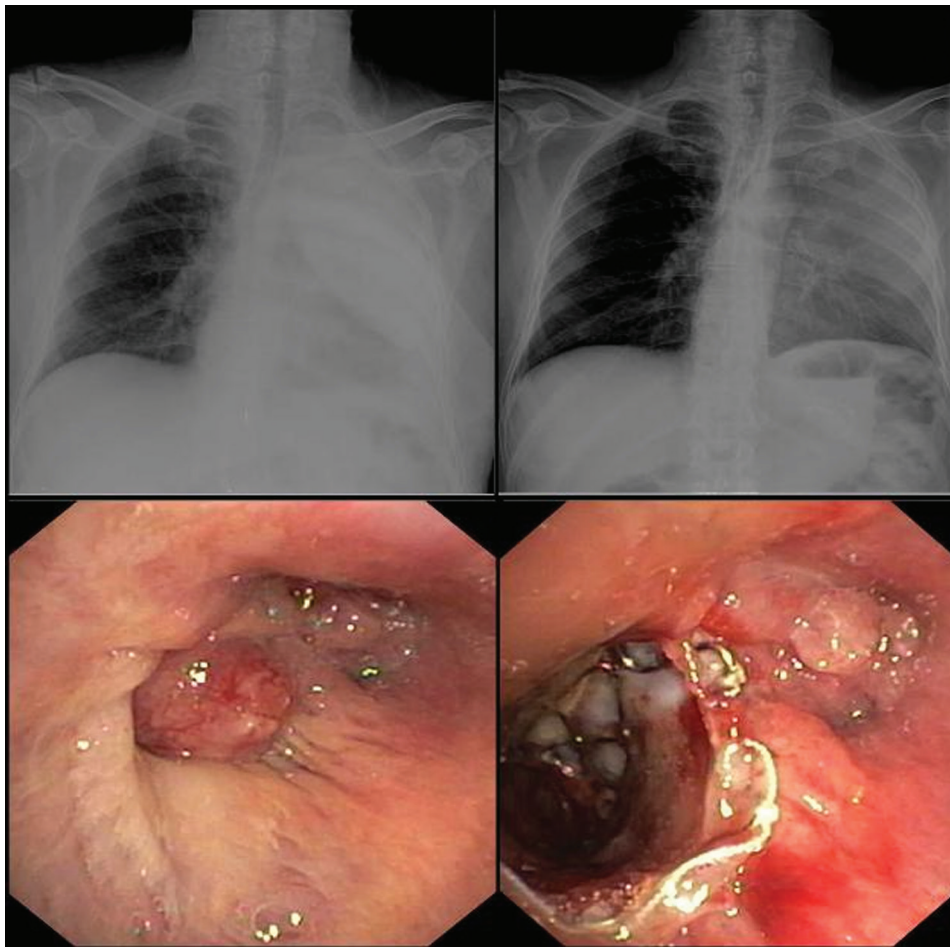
Complex stenosis of the left lower lobe bronchus. A Silmet stent was inserted to drain the malignant post-obstructive abscess. Chest radiography performed after stenting showed the emptied cavity
